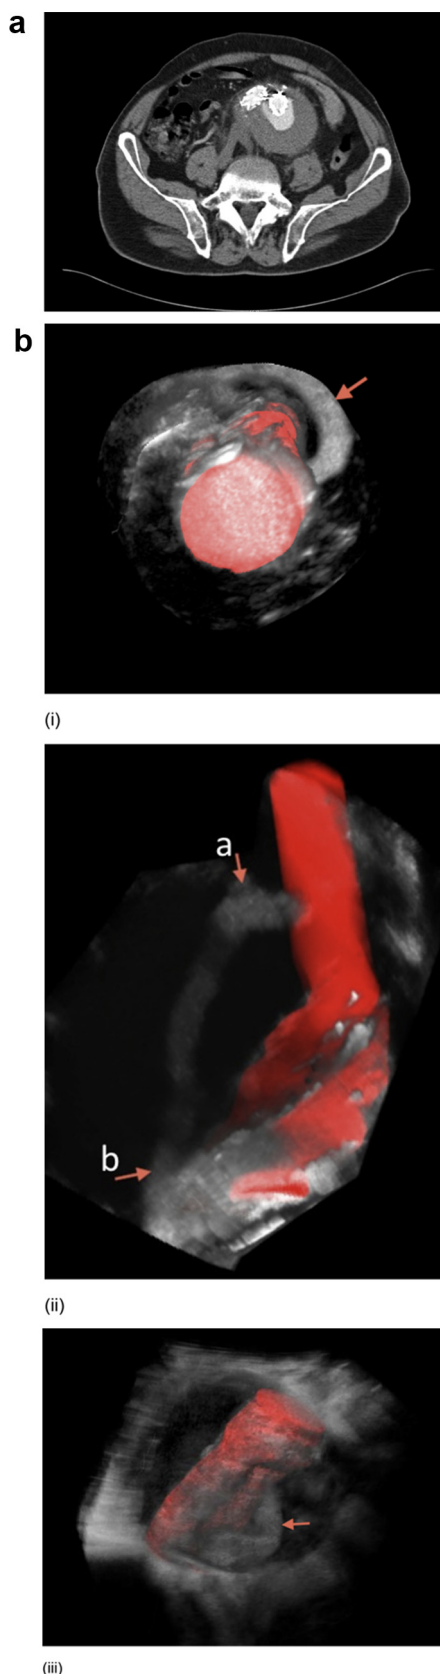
(A) CTA showing Type II endoleak. (B) 3D CEUS of same subject showing a Type II endoleak (red arrows) flowing from the (a) inferior mesenteric artery (b) to a lumbar artery. The stent-graft is coloured red by the 3D ultrasound software to distinguish flow
